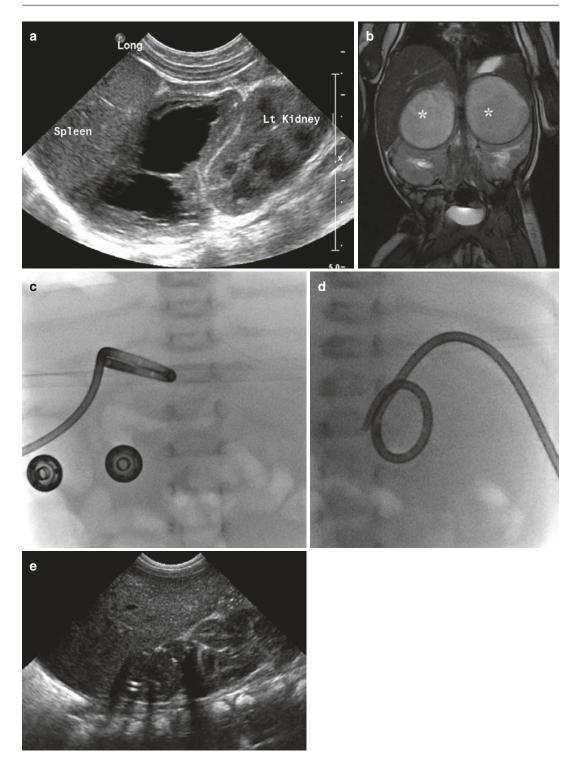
Infected adrenal haematomas. Annotated ultrasound image (a) shows irregular thick walled cystic suprarenal mass. Bilateral adrenal collections (b-e). Single coronal MR image demonstrates large bilateral
